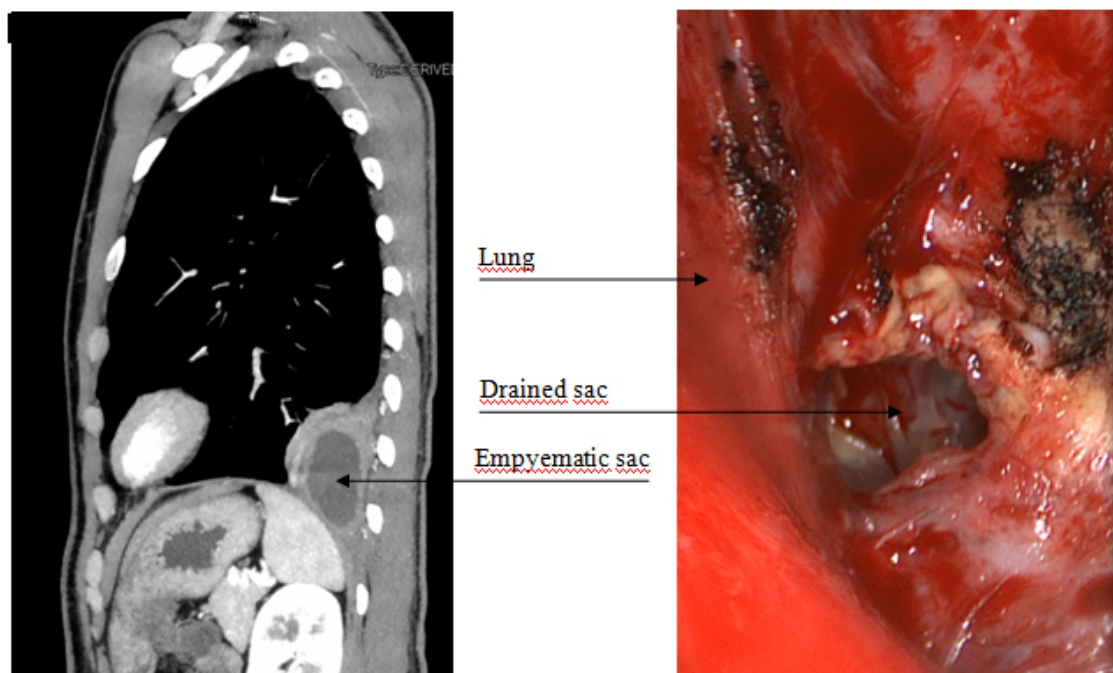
CT scan and videothoracoscopic view of the empyematic sac
